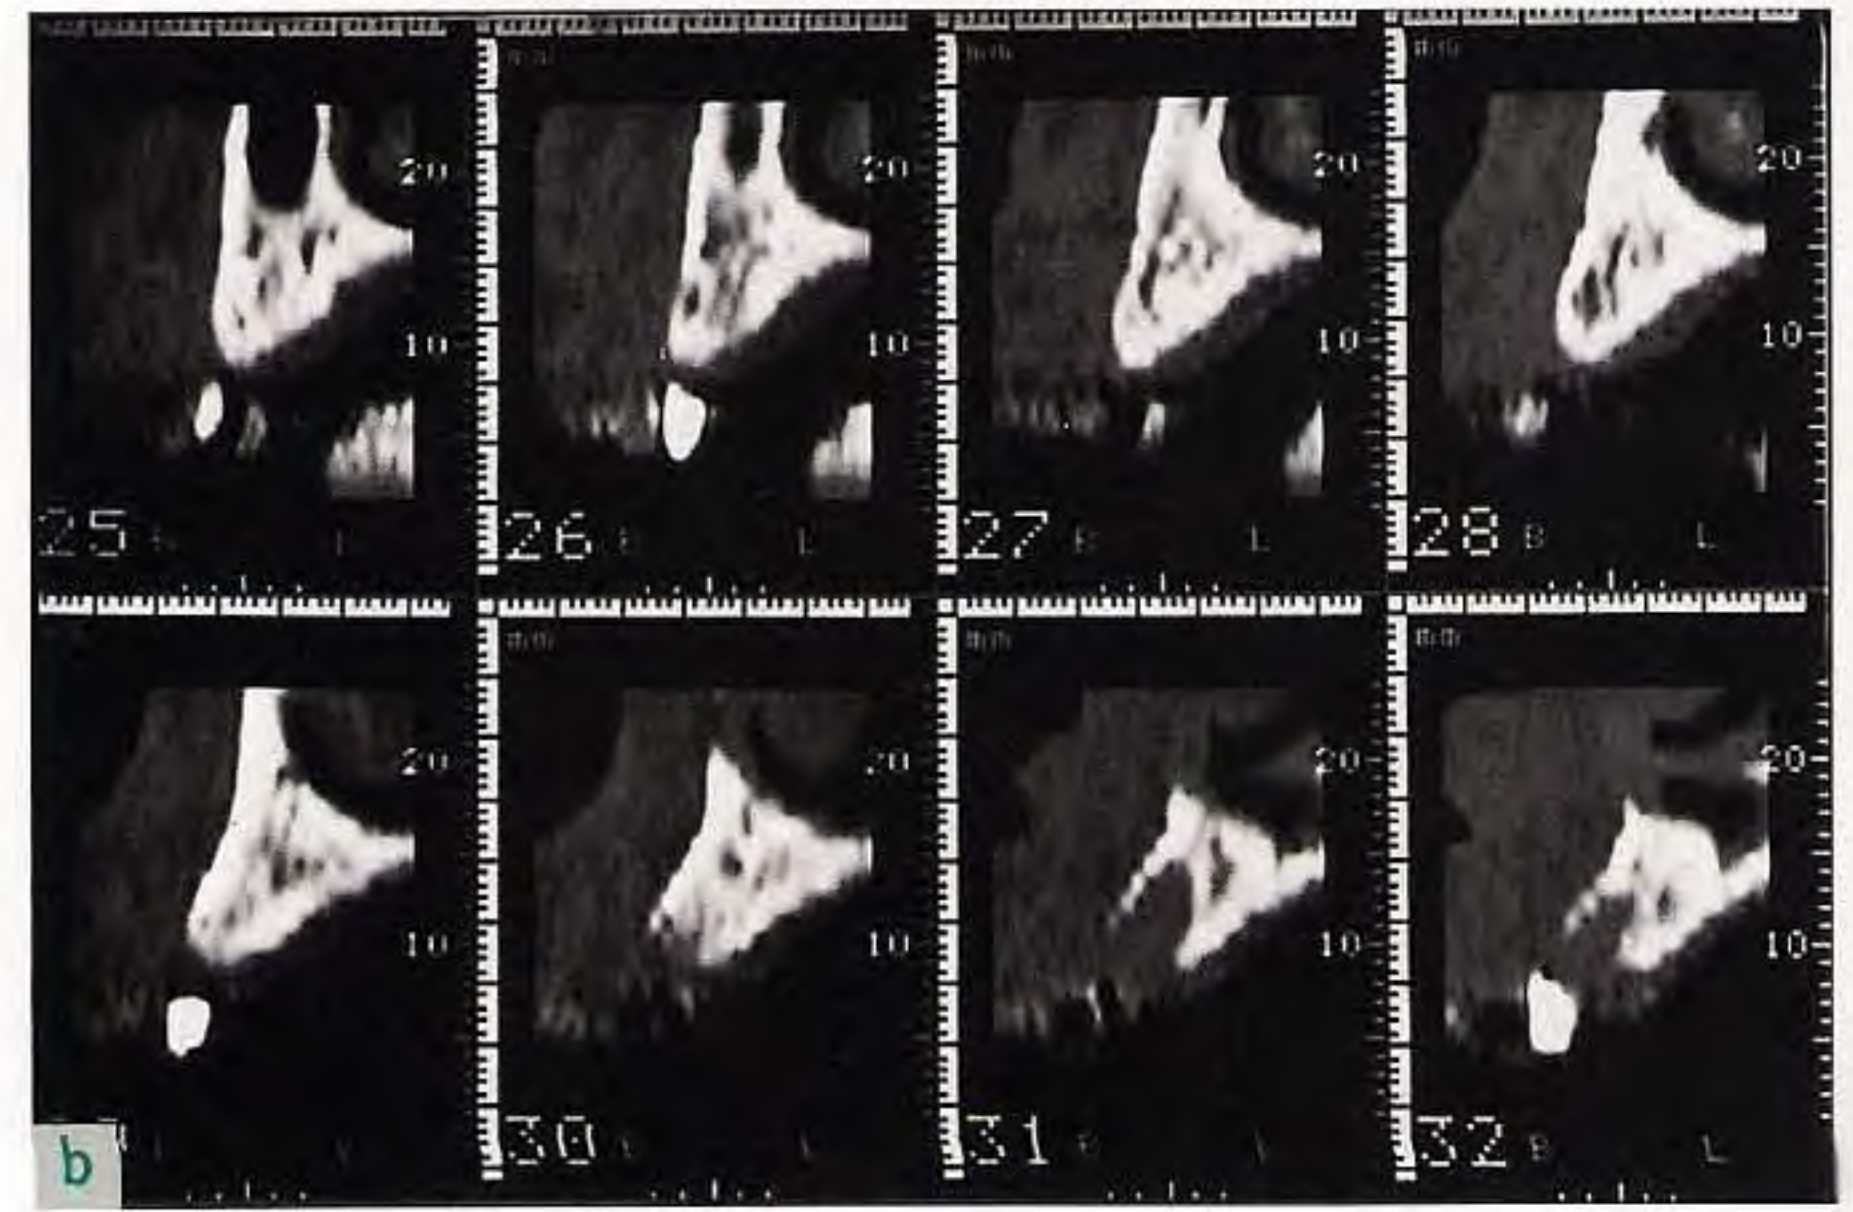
Preoperative procedure. (a) Radiographic mask or template (prepared with gutta-percha inserts); (b) CT scans; note the radiopaque markers in sections 26, 29, and 32; (c) modification of the radiographic template to a surgical template; (d) intraoperative use of the surgical template.
